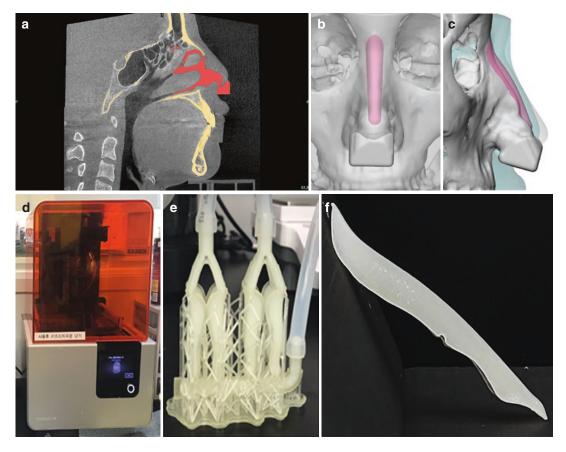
Fabrication of patient-specific nasal implants. (a) Acquisition of 3D information of human tissue through medical images such as CT or MRIs and segmentation of specific area from the patient medical image. (b, c)
